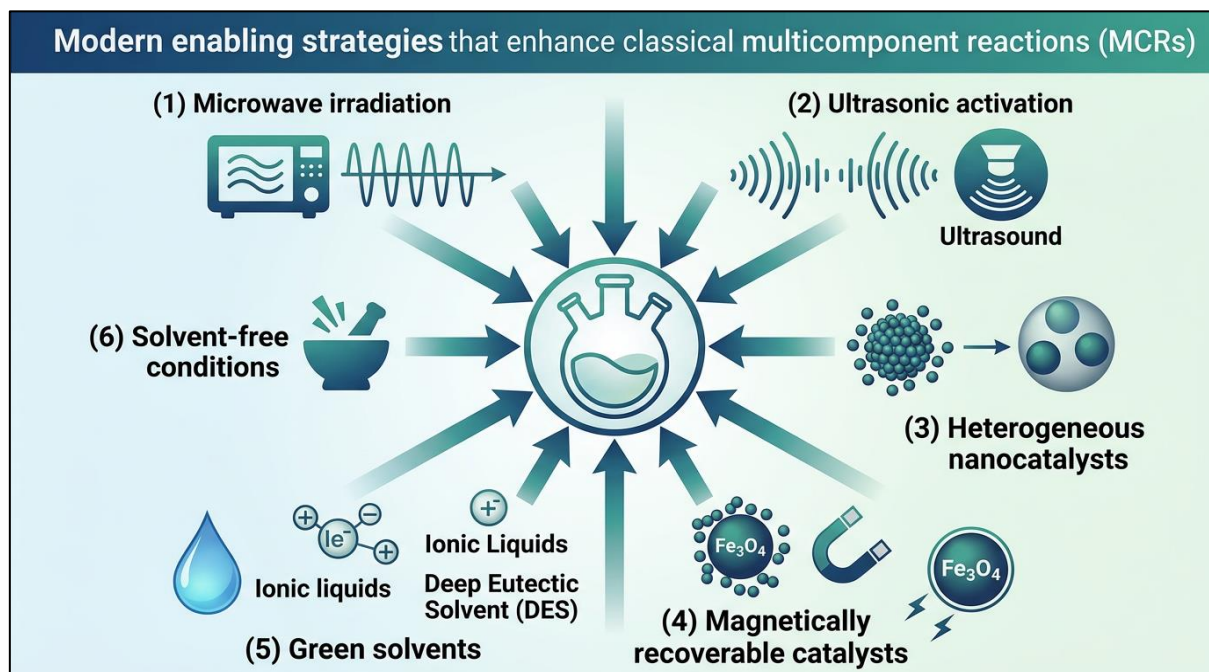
Modern Enabling Strategies that Have Refined the Classical MCRs. Microwave and Ultrasonic Activation, Heterogeneous and Magnetically Recoverable Nanocatalysts, Aqueous Media, Ionic Liquids/Deep Eutectic Solvents, and Solvent-Free Protocols Converge on the same Multicomponent Vessel to Cut Time, Energy and Waste While Extending the Scope of these Reactions.
